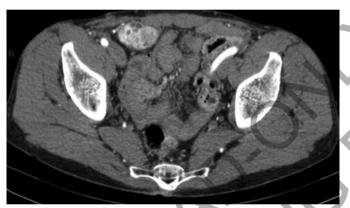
CT scan images. Contrast enhanced CT-scan showed a well demarcated oval mass with microcysts vascularized in the arterial phase.
